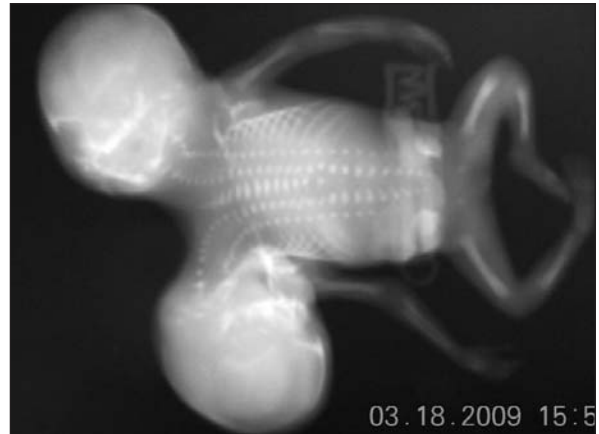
X-ray view of conjoined twin case: Single or conjoined two vertebral colon(s) and one sacrum.
